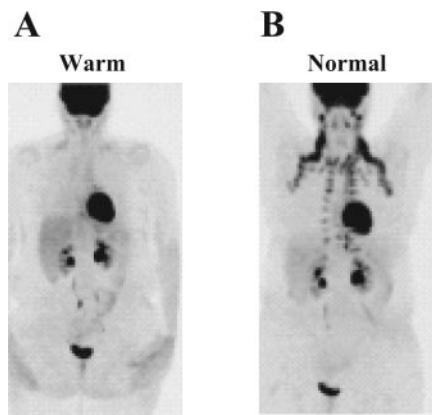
Cold-induced brown adipose tissue activation in adult man. The same patient was investigated by fluorodeoxyglucose positron emission tomography (FDG PET) twice a few days apart. *A*: efforts had been made to keep the patient under warm conditions before injection and during the time from injection to imaging. The only uptake visible is that into the brain, heart, kidneys, and bladder. *B*: the patient had been examined under routine conditions, i.e., in comparatively cold conditions. Note that the characteristic symmetrical pattern of uptake into the supraclavicular, neck, paravertebral areas, etc., i.e., into brown adipose tissue, is now visible. Reproduced from Christensen et al. (17) with permission.
